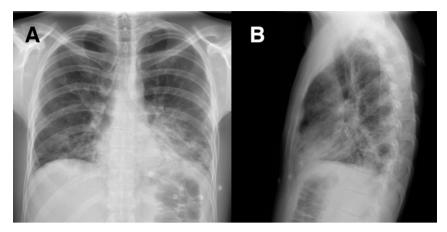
Initial simple-chest-X-ray. Posterior-anterior (PA) projection. It shows diffuse bilateral basal infiltrates.
